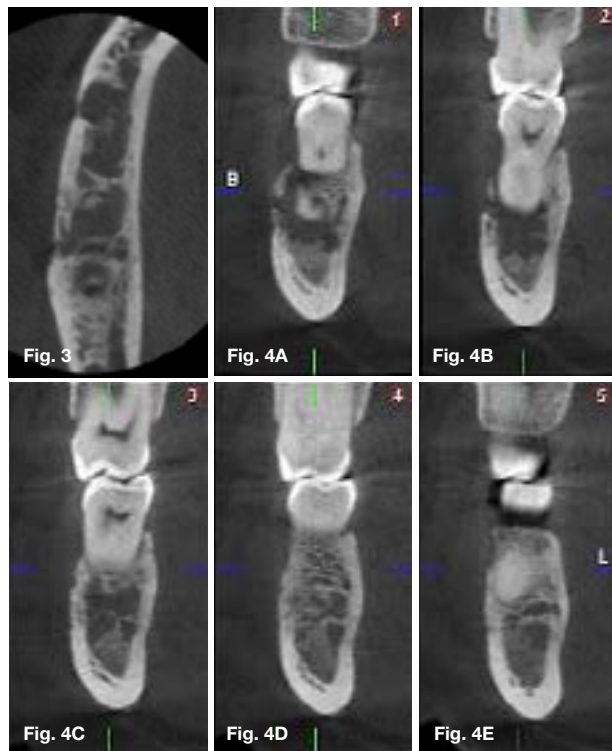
Axial and coronal CBCT images showing destruction of the buccal cortical plate
